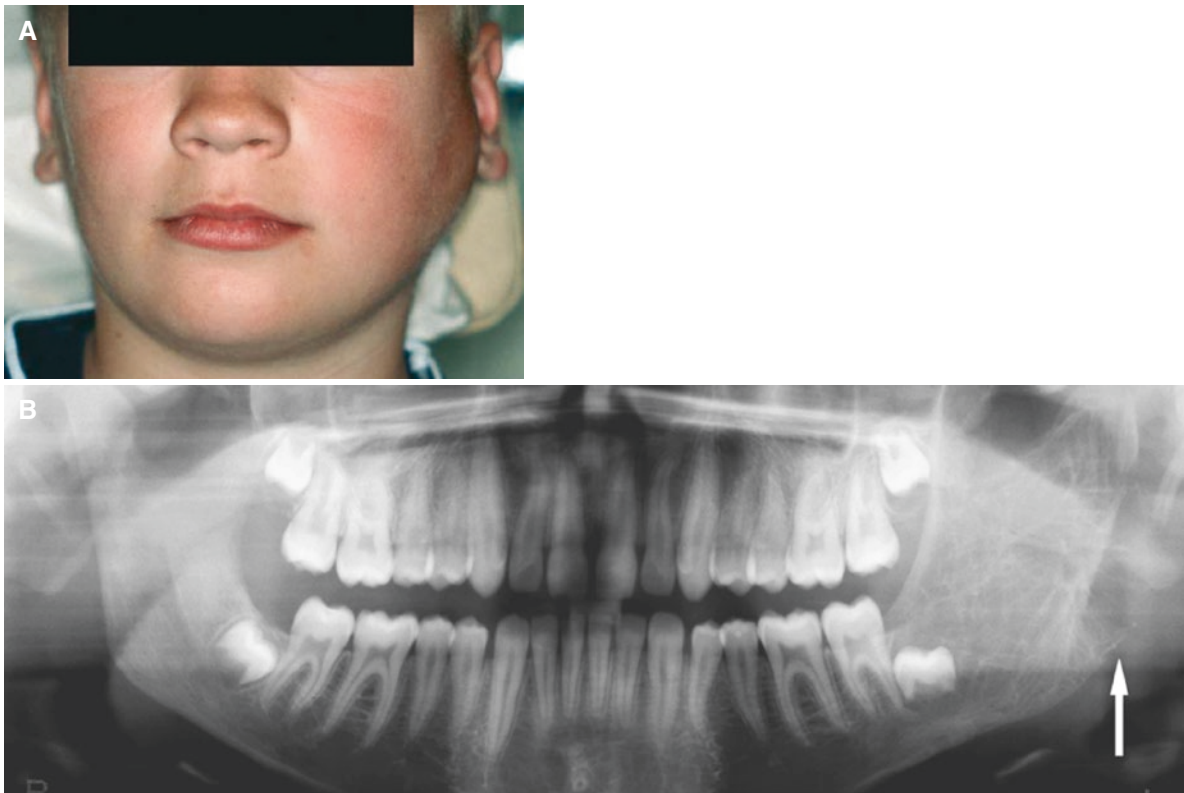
Osteoblastoma, mandible; 10-year-old male with painless swelling of the left cheek, parotid region. (A) Clinical photograph shows swelling of the left parotid area. (B) Panoramic view shows expansive process in the ramus with coarse trabecular pattern (arrow). (C) Axial CT image shows expansive, osteolytic process with gracile structure (arrow). (D) Coronal CT image shows expansive process with thin but rather well-defined border (arrow). (E) Coronal CT image
